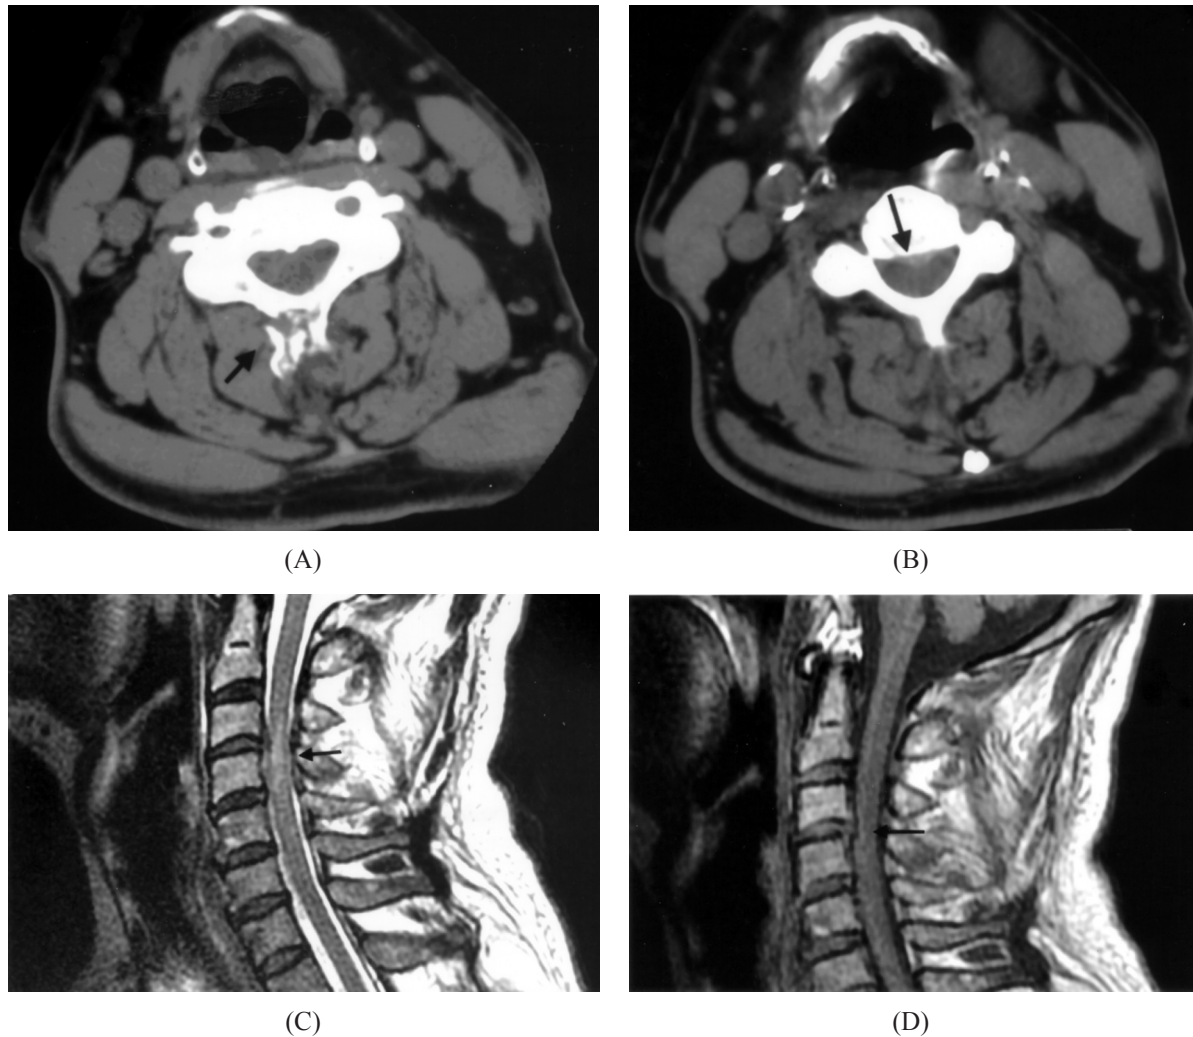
CT scans of the C-spine without IV contrast shows (A) C4 spinal process fracture and (B) Central herniated intervertebral disc at C3/4-C4/5 with slight compression to the spinal cord. (C) Sagittal T2- and (D) T1-weighted MR images of the cervical spine without IV contrast medium enhancement revealed C3-4 retrolisthesis with displacement of the posterior longitudinal ligament, resulting in the narrowing of the spinal canal and spinal cord myelopathy.
